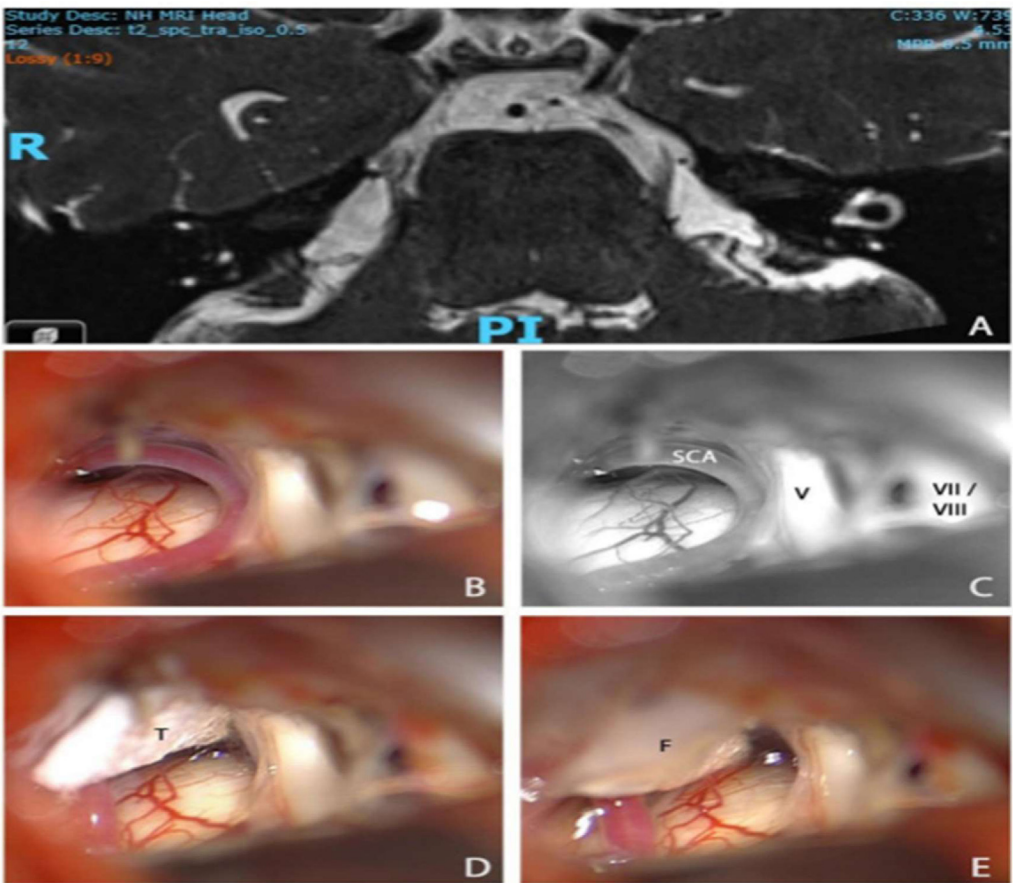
MRI scan of trigeminal nerve (A) and intraoperative pictures (B–E) during microvascular decompression from a patient with TN.
